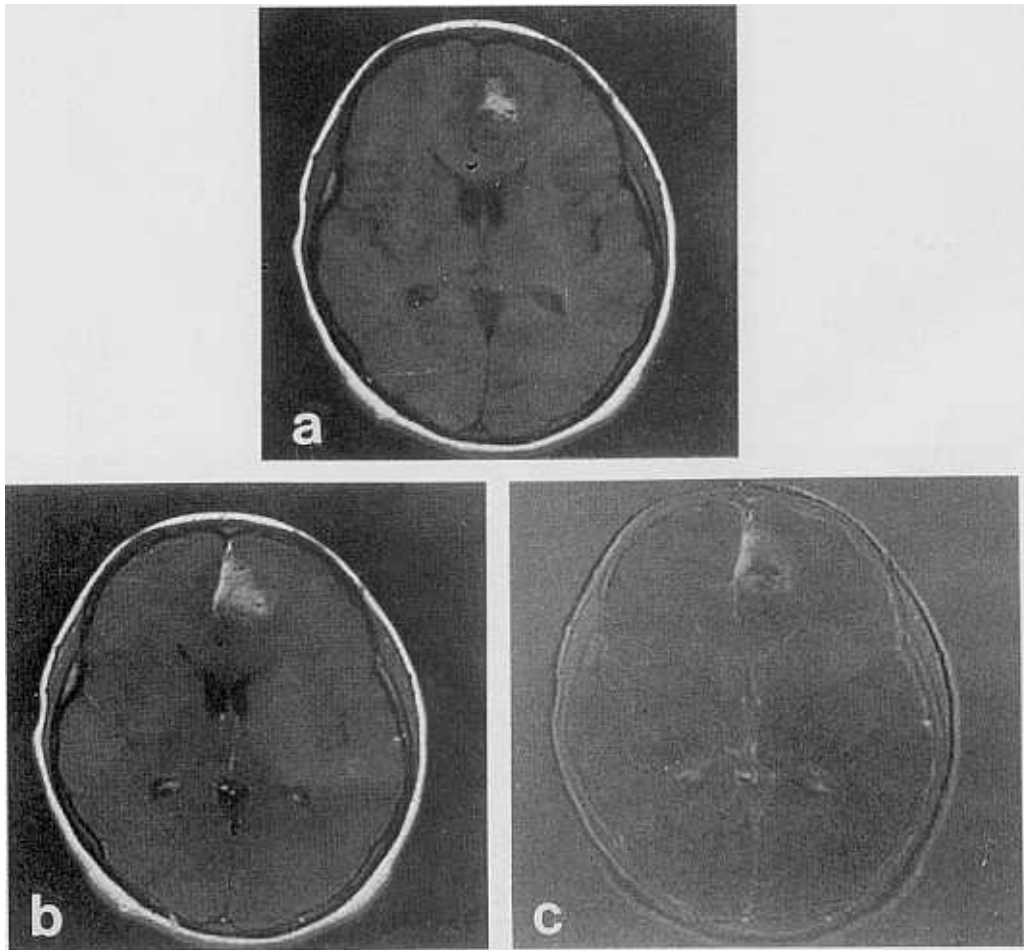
Above figures are (a) T1 MR image, (b) Gd-DTPA enhanced image with same parameters as (a), and (c) subtraction image (a-b). Enhanced regions are seen more clearly on the subtracted image.
